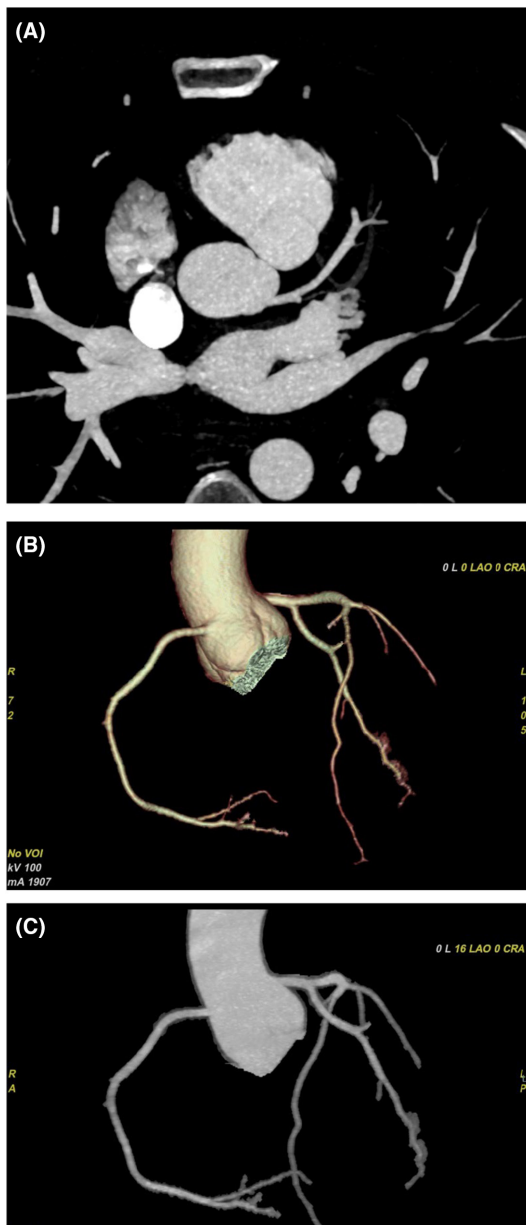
Final follow-up, 1 year after initial presentation. A coronary computed tomography scan with three-dimensional reconstruction at images (A–C, and) shows complete interval resolution of the previously visualized left anterior descending artery intramural hematoma, with resolution of the outpouching structure.
